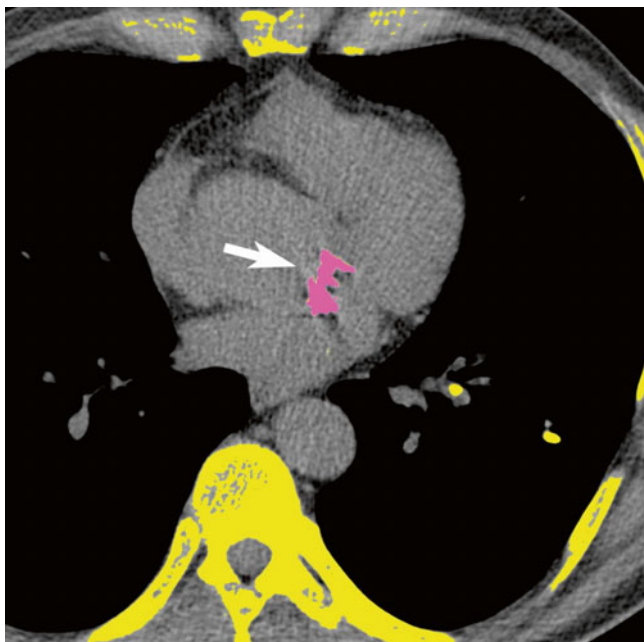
Axial, non-contrast CT image in a patient with moderate aortic stenosis, demonstrating the quantification of aortic valve calcium (arrow) using the same approach as for coronary calcium scoring. The valvular calcium score (“Agatston”) was 2227
